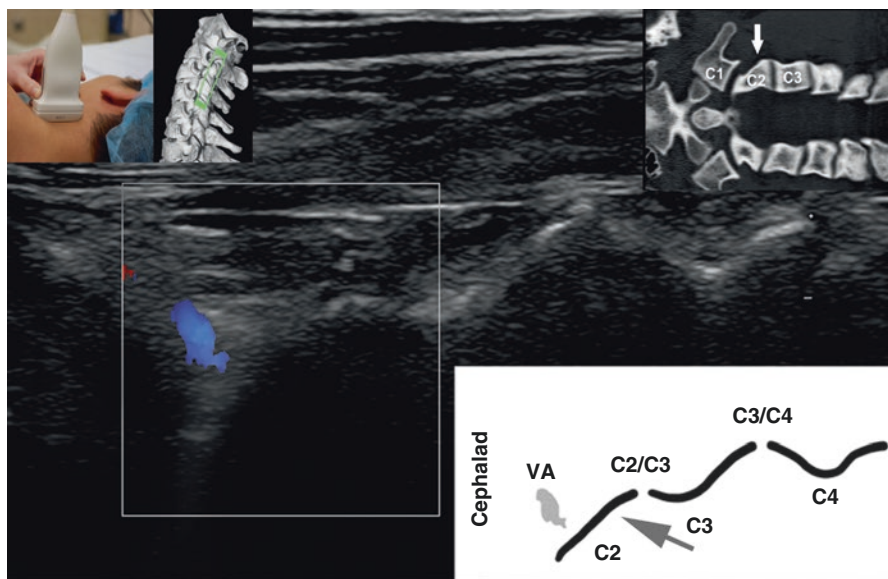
Coronal scan of the upper cervical spine demonstrating the drop-off formed by the inferior articular process of C2 (grey arrow in right lower inset), the vertebral artery (VA) can be imaged with duplex Doppler immediately cephalad. This view facilitates identification of the C2/C3 joint which is used as a landmark during third occipital nerve blocks. The right upper inset is a coronal CT scan of the cervical spine demonstrating the drop-off formed by the inferior articular process of C2 (grey arrow). (Reprinted with permission from Philip Peng Educational Series)
